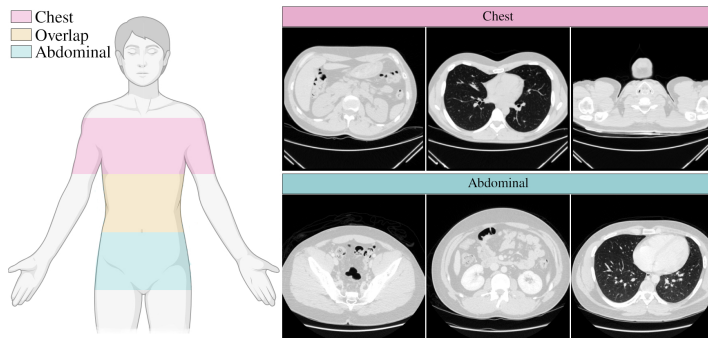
Comparison of chest and abdominal CT volumes. Top row: representative axial slices (first, center, last) from a chest CT volume, spanning from caudal to cranial directions (left to right). Bottom row: corresponding slices from an abdominal CT volume processed with the same spatial dimensions.
